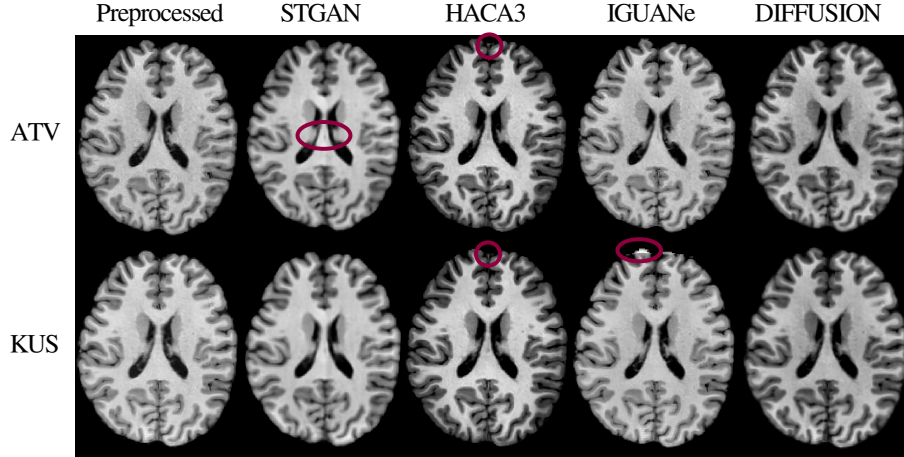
Visualization of harmonized MR images for each method.* Central axial slice of one SRPBS subject (sub-1) for two different sites (ATV and KUS) are displayed. Inconsistencies (missing details or artifacts) are circled in red.
